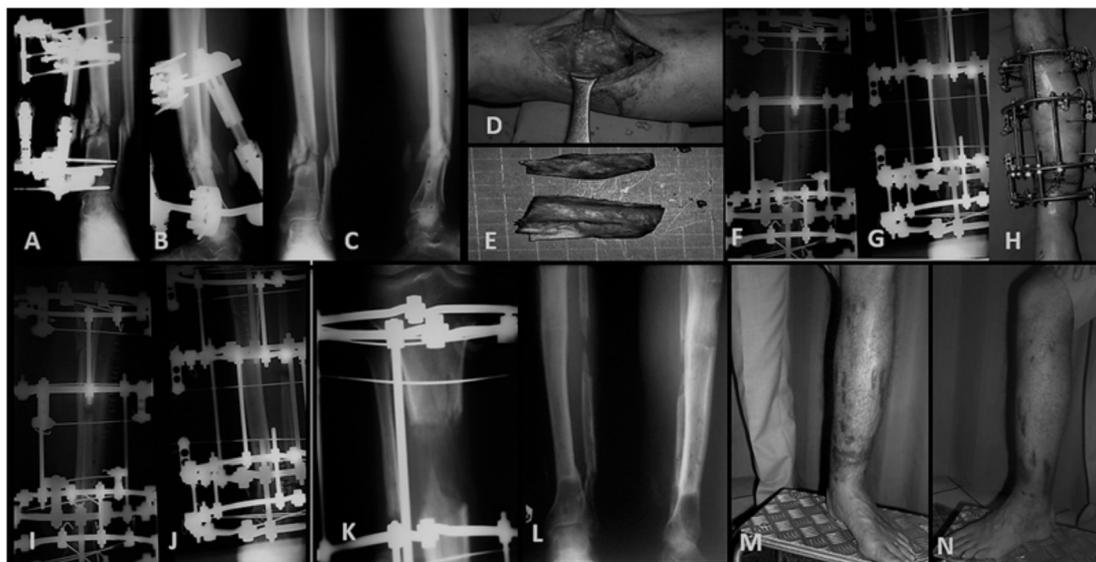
42-year-old male. A, B) open fracture according Gustilo Anderson classification type IIIB of the distal leg extremity treated with external fixator frame; C) After 6 months there was Cierny Mader IV A: widespread bone marrow and cortical infection with multiple seizures on the bone periphery but free from systemic pathologies or severe local impairment; D, E) Bone resection; F,G,H) Implantation of the Ilizarov's frame; I, J) Proximal corticotomy after 4 weeks; K) X-ray of regenerated bone after 3 weeks of teriparatide injection; L) X-rays after removed of Ilizarov's frame shows an excellent regeneration is an excellent result according to ASAMI classification; M, N) Excellent clinical and aesthetic results (Meccariello L. 2016)
